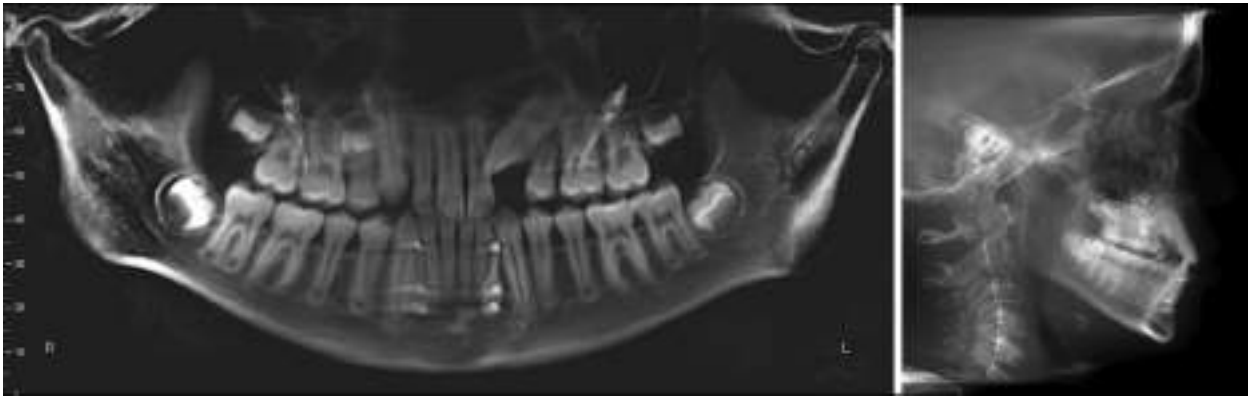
Panoramic and cephalometric radiographs.
